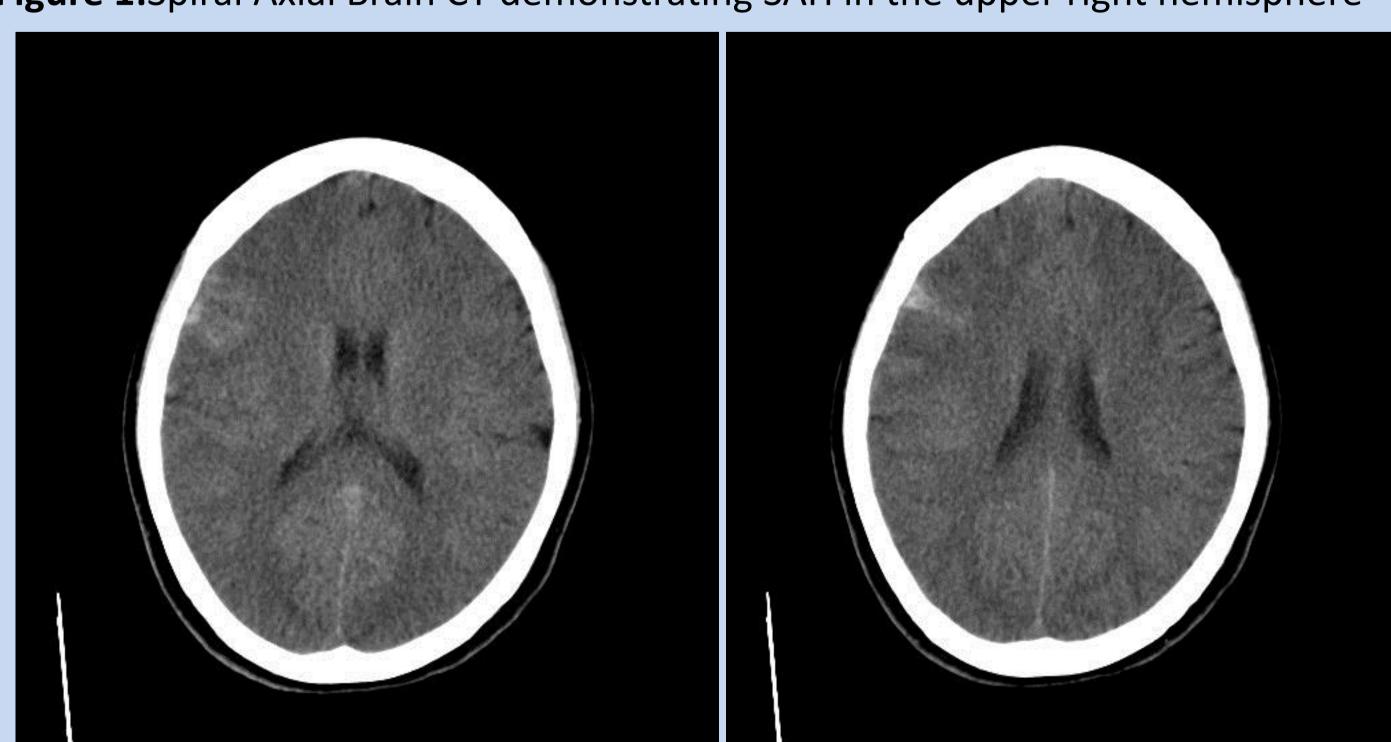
Spiral Axial Brain CT demonstrating SAH in the upper right hemisphere
